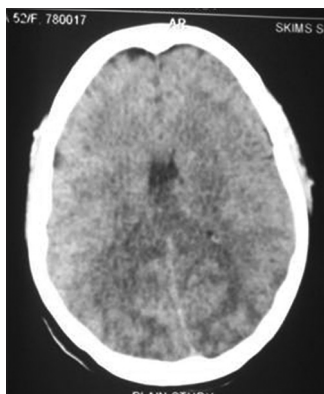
Noncontrast computed tomography head suggestive of diffuse brain edema
